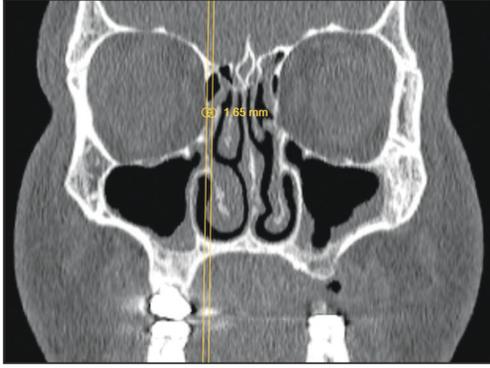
Coronal CT image showing the localization of the lamina papyracea relative to the middle meatal anastomy point, based on the Herzallah classification
